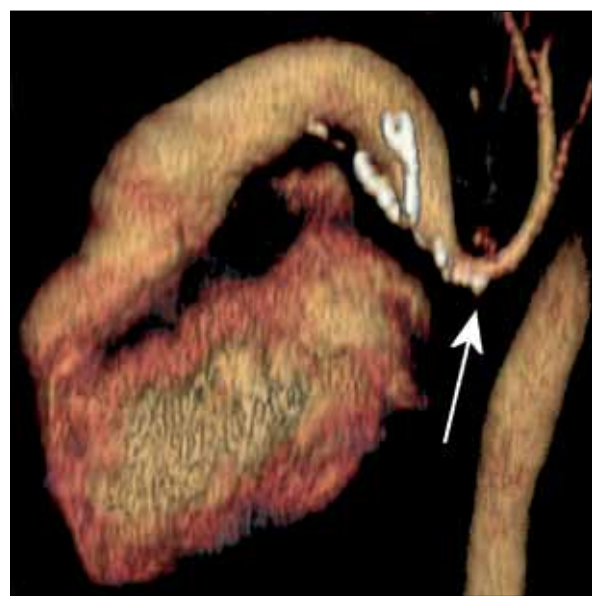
Volume-rendered computed tomographic image from the left side of the patient showing an anticlockwise twist of the left pulmonary artery, centred on the hilum, with a cranial instead of a normal caudal course (arrow)
